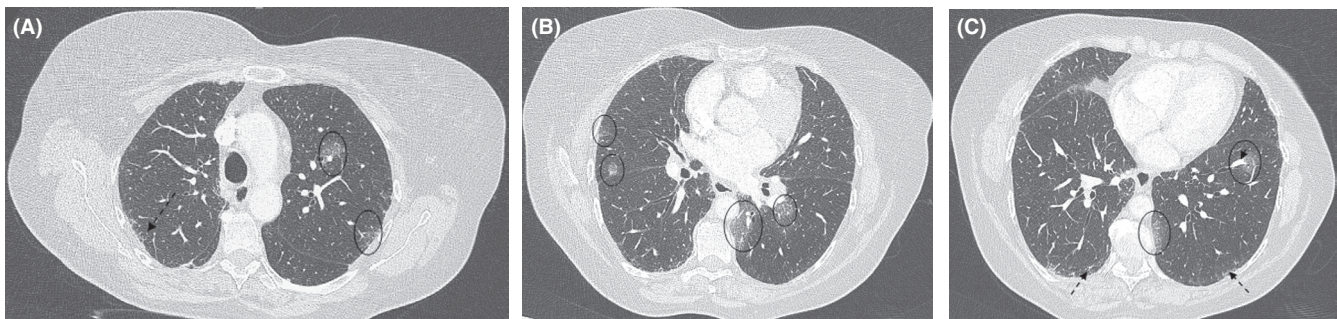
A-C, Axial chest CT images showing linear reticular subpleural opacities (Dashed black arrows), multifocal, bilateral subpleural and peri-bronchovascular patchy and nodular ground-glass opacities (Black circle), involving 5%-25% of the lung parenchyma with dilated vessels (Black arrow head) and traction bronchiolectasis in the affected areas
